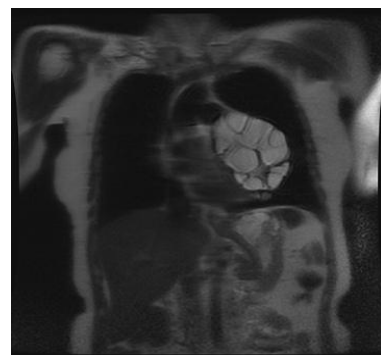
T2-weighted coronal spin-echo MR image shows high signal intensity multilocular cystic lesions in the pericardium.
